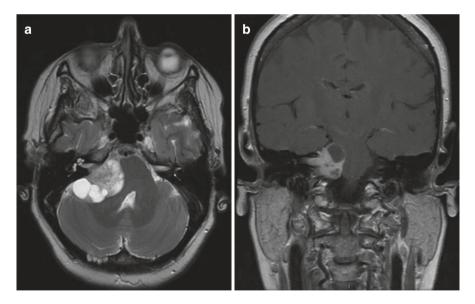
T2 axial (a) MRI and T1 with gadolinium coronal section (b) showing right acoustic neuroma
